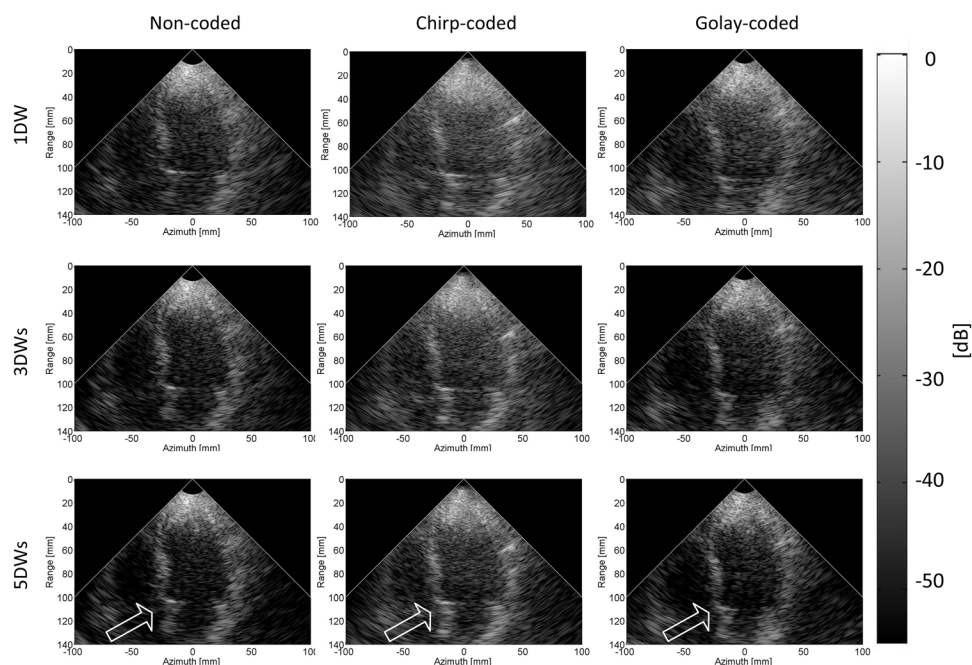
In vivo* images of the left ventricle of the human subject in the apical four chamber view acquired from different imaging schemes, including non-coded DW, chirp-coded DW and Golay-coded DW schemes with 1, 3 and 5 DWs compounding, respectively.
